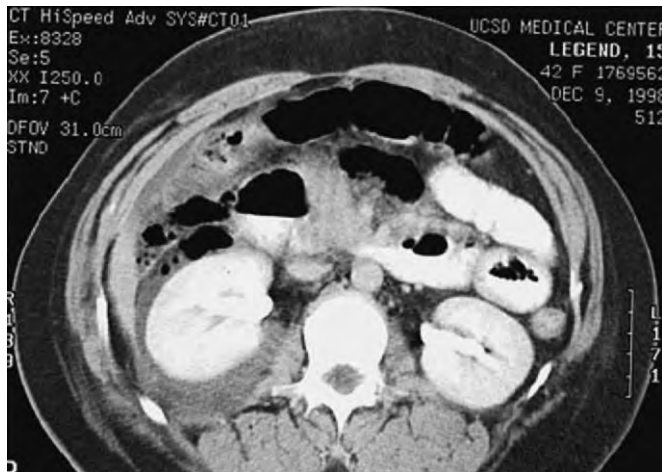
Computed tomography scan demonstrating retroperitoneal air and edema. (From Hoyt DB, Coimbra R, Potenza B: Management of acute trauma. In Townsend CM, Beauchamp RD, Evers BM, Mattox KL [eds]: *Sabiston Textbook of Surgery*, 17th ed. Philadelphia, WB Saunders, 2004, p 516.)
